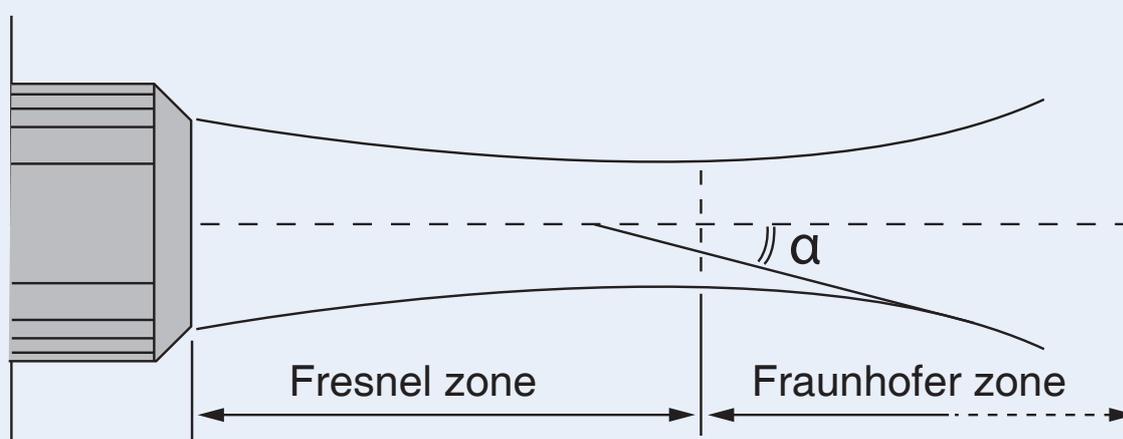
Lengthwise section of the ultrasound bundle
